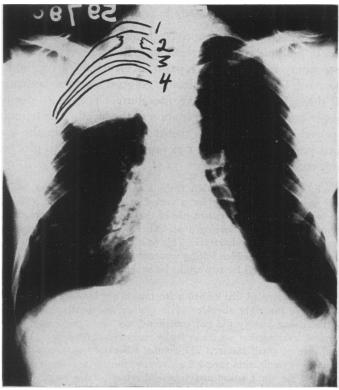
Case 3: Overexposed roentgenogram revealing a peripheral squamous cell carcinoma of the lung, with destruction of the 2d rib.
